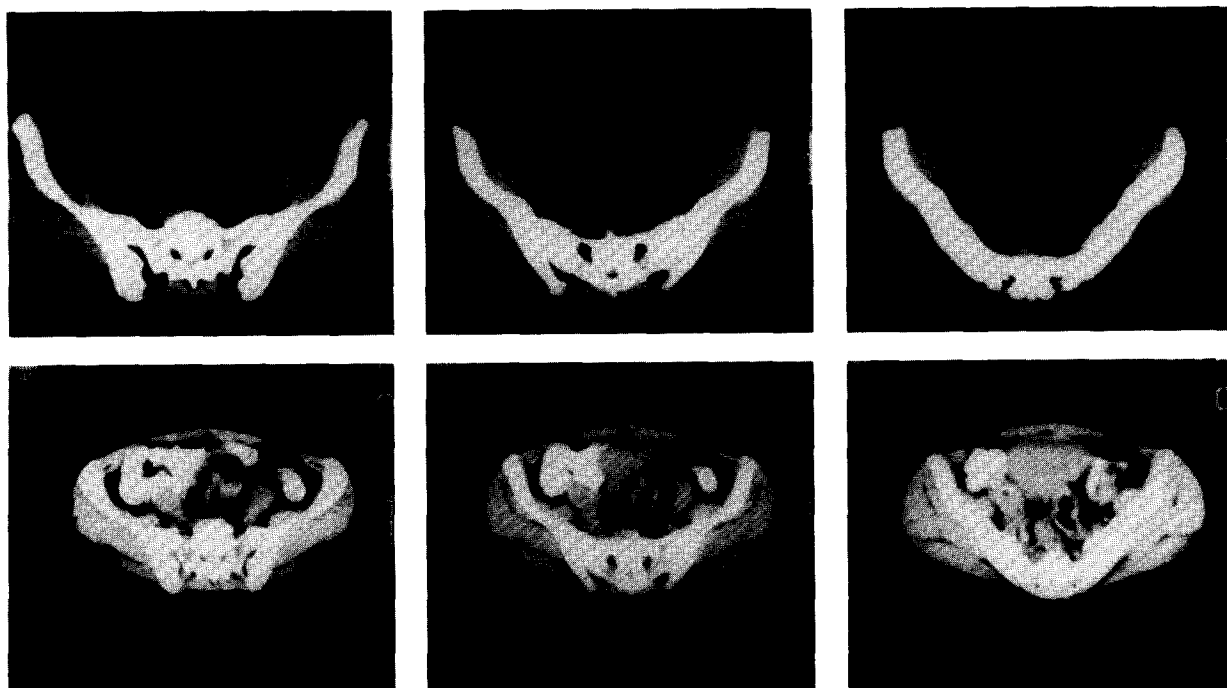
Pelvic CT scan images before and after treatment of a 19 year old patient presenting with massive primary mixed OGCT with para-aortic nodes and liver metastases. The patient was treated with POMB/ACE chemotherapy. At the end of chemotherapy cysts were removed at laparotomy from both ovaries but these contained no residual malignancy.
